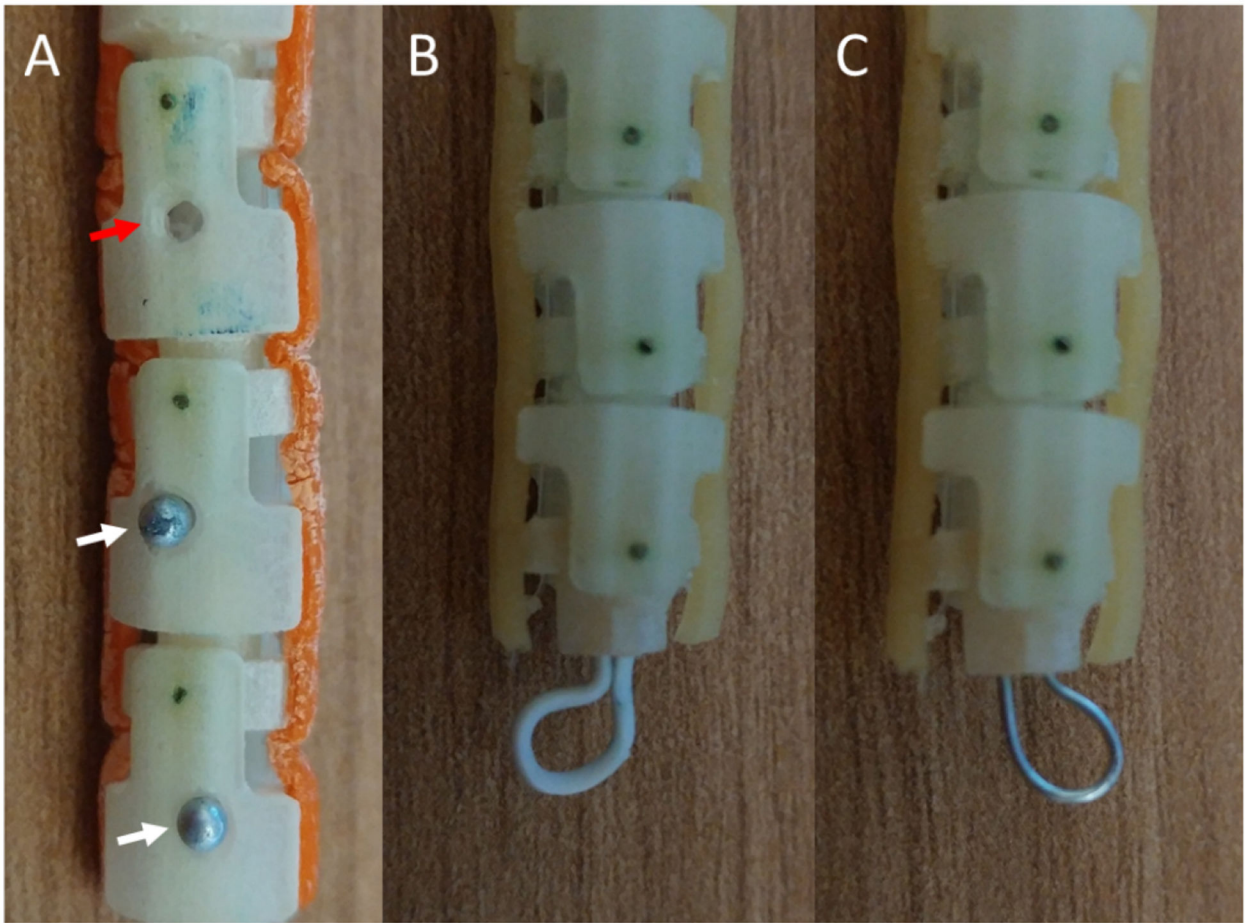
Different approaches to fiducial markers for improved orientation estimation under ultrasound visualization. A) Holes (red arrow) and partially recessed steel pin heads (white arrows) as fiducial markers on a robotic catheter. B) A plastic-coated steel wire loop fiducial attached to the tip of the catheter. C) A similar loop fiducial made using an uncoated steel wire.
